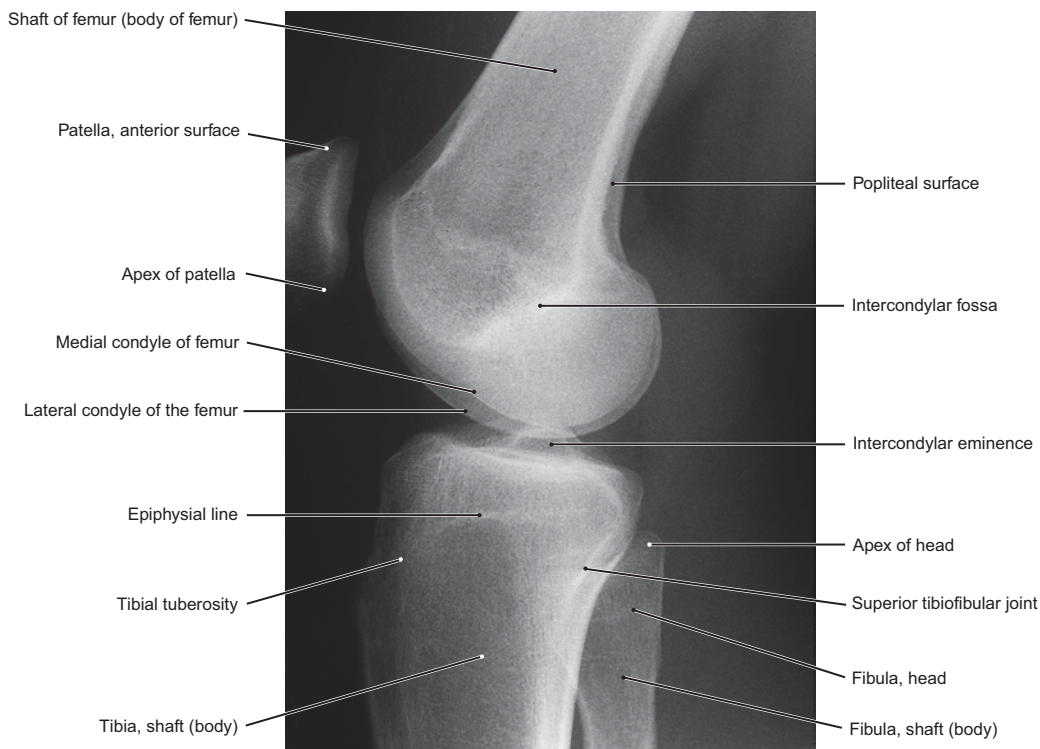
Lateral Radiograph of the Knee Joint
